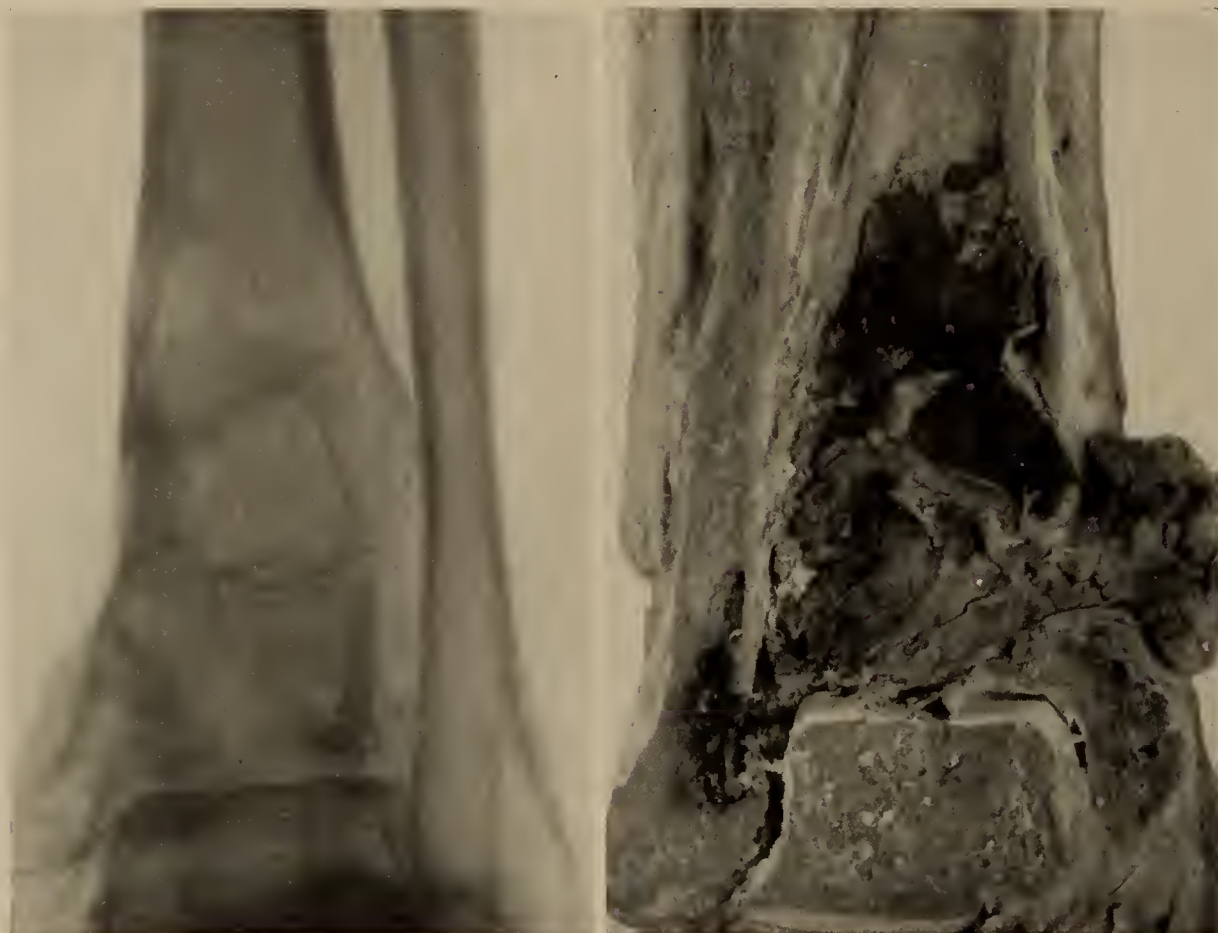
Case 212. Giant cell tumor in a man 24 years old. Curettage on several occasions led to a persistent sinus with tumor sprouting through it. The roentgenogram was taken before the amputation, 2 years and 2 months after the onset. The roentgenogram and especially the photograph show the spreading of the tumor along the tibia—fibular attachment into the fibula.
